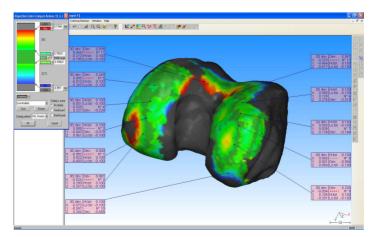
Knee-joint – the map of deviations of shape mapping as the comparison of the imposition of the surface derived from the CT studies with the surface obtained from studies on CMM.
